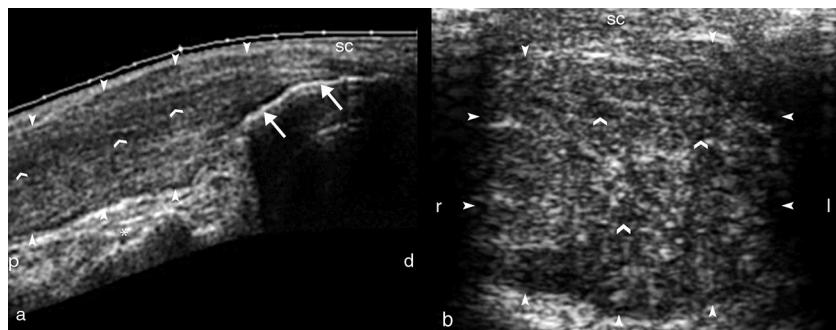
1a) Achilles tendon ultrasound extended in the longitudinal plane (P = proximal; D = distal) and 1b) cross-sectional plane (D = right; E = left) showing marked diffuse and concentric thickening of the Achilles tendon (arrowheads mark the tendon external margins) predominating in middle- and distal sections with a diffuse heterogeneity, with confluent hypoechoic areas (open arrows) and thin hyperechoic foci within the tendon being observed, which cause a loss of the fibrillar pattern of tendons. Arrows delineate calcaneus cortical bone, (*) demonstrates Kager fat pad and (sc) is the subcutaneous tissue. No hyperechoic masses are seen in the tendon despite the extensor involvement of the tendon.
